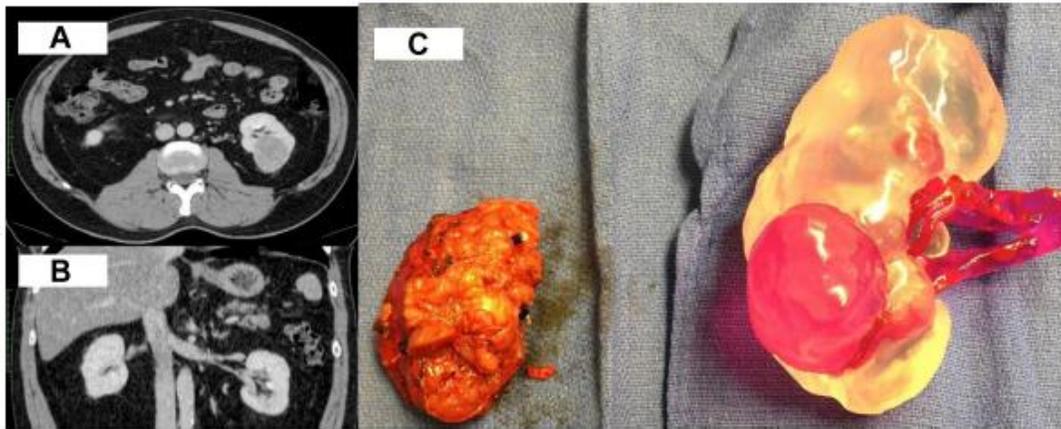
(A,B) Select transverse and sagittal CT images of a 57-year-old man (patient 3) with a left lower pole posterior enhancing renal mass. (C) Resected left renal mass next to 3-dimensional physical model of left kidney (turned posterior) including major renal vasculature constructed from CT scan. CT, computed tomography.
